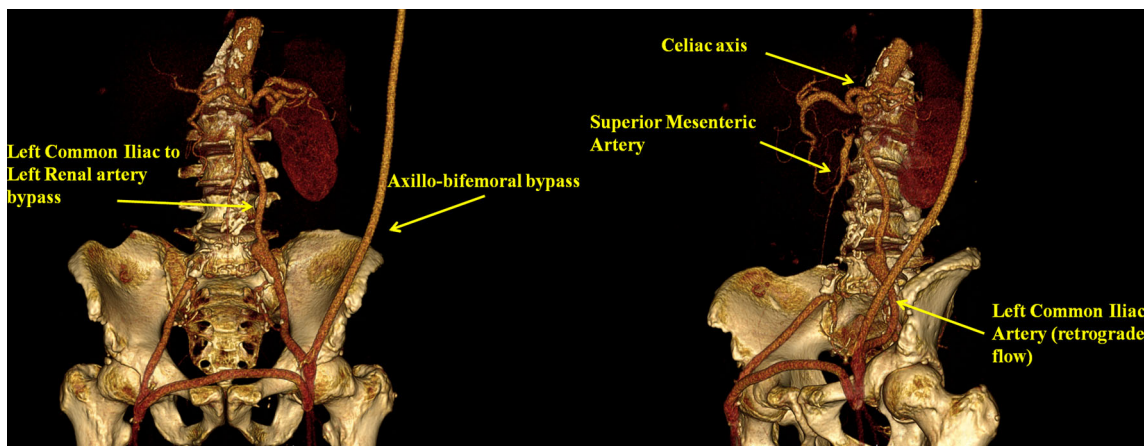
CT imaging at 12 months revealed good graft patency
